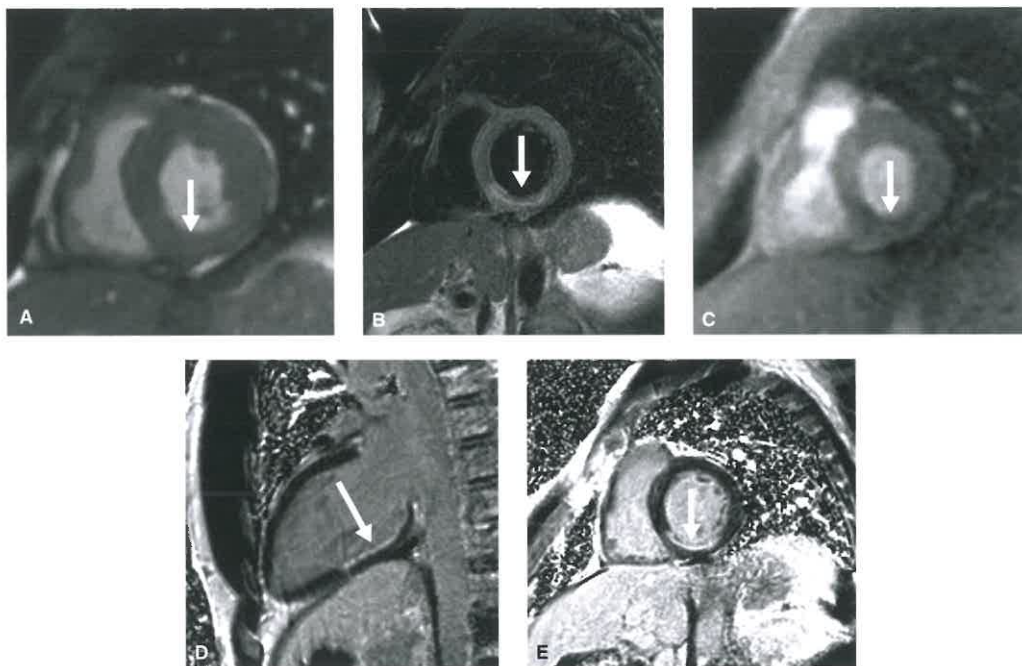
Subacute Myocardial Infarct in the RCA Distribution in a Patient With Right Coronary Artery Dominance but a Relatively Small Posterior Left Ventricular Branch. A: Short axis image through the base of the left ventricle from a cine SSFP sequence shows mild thinning of the inferior segment which was hypokinetic (*white arrow*). B: T2-weighted triple inversion recovery image through the base shows subendocardial high signal due to edema from recent infarct (*white arrow*). C: Short-axis perfusion image at the base shows subendocardial hypoperfusion which can be seen with ischemia or infarct (*white arrow*). D, E: Short-axis (D) and two-chamber (E) LGE images show thin subendocardial delayed enhancement (*white arrows*) involving the inferior segment at the base and mid-cavity level consistent with infarct. Given that the enhancement is less than 50% of the myocardial thickness, the underlying myocardium is considered viable, and the patient is likely to recover function after reperfusion.
